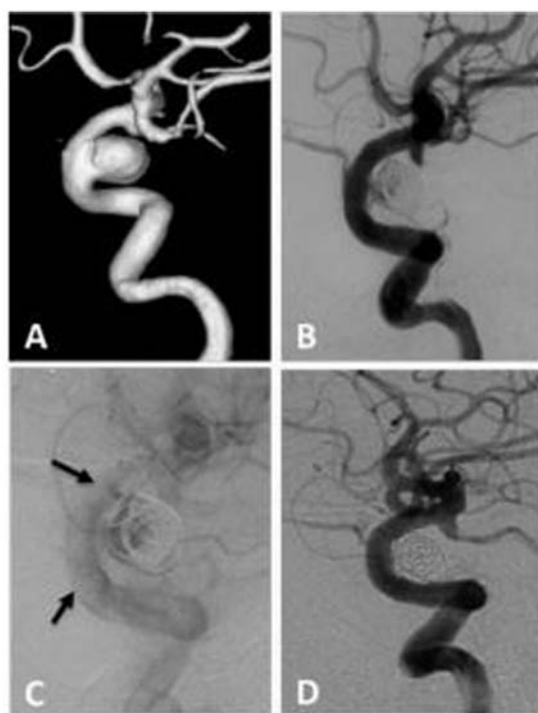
Carotid siphon aneurysm treated with the Willis covered stent plus coils. (A) Pre-procedural three-dimensional rotational view shows a wide-necked large aneurysm on the C4 segment of the internal carotid artery. (B) Cerebral angiogram immediately after stent-assisted coil embolization shows near total occlusion of the aneurysm with mild endoleak. (C) The Willis covered stent can be clearly seen in the plain film after stent placement (arrows). (D) Follow-up angiogram at 12 months shows complete disappearance of the aneurysm with patency of the parent artery.
